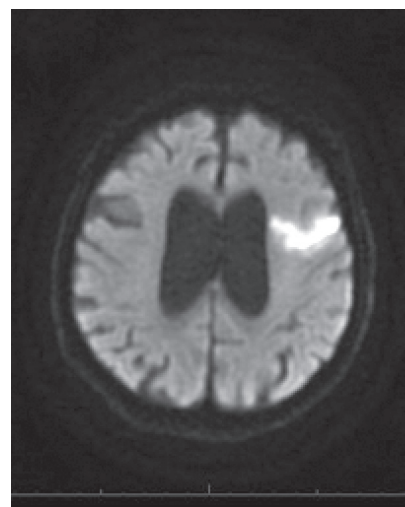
Axial magnetic resonance imaging of the brain showing recent infarct.
